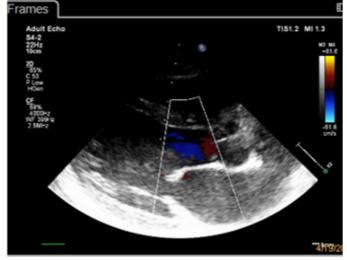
Bidimensional echocardiography. Parasternal long axis. There is no mitral regurgitation.
